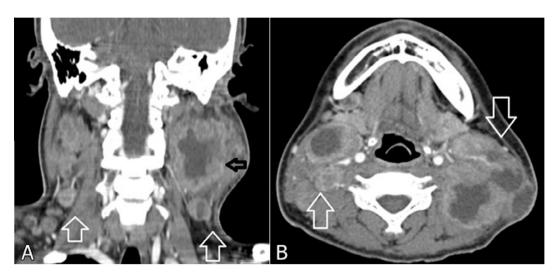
(A) Axial CT picture showing multiple enlarged cervical, submandibular and supraclavicular lymph nodes bilaterally with some central necrosis (arrows). (B) Coronal CT picture showing bilateral multiple nodes (white arrows) with the largest node measuring 5.9 cm × 6.1 cm × 7.7 cm, at the left neck posterior triangle (dark arrow).
